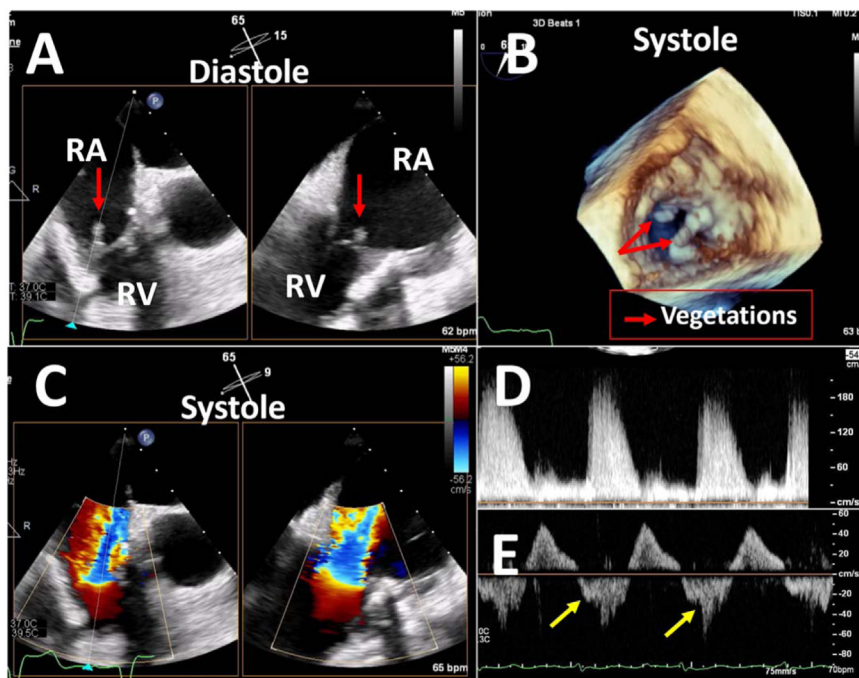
Example of bioprosthetic TV with severe regurgitation. TEE shows multiple vegetations (red arrows, A and B) on the bioprosthetic TV, resulting in severe regurgitation (C). CW Doppler (D) shows a low-velocity dense and early systolic peaking profile. PW Doppler of the hepatic vein (E) shows systolic flow reversal (arrows) consistent with severe regurgitation. RA, Right atrium; RV, right ventricle.
